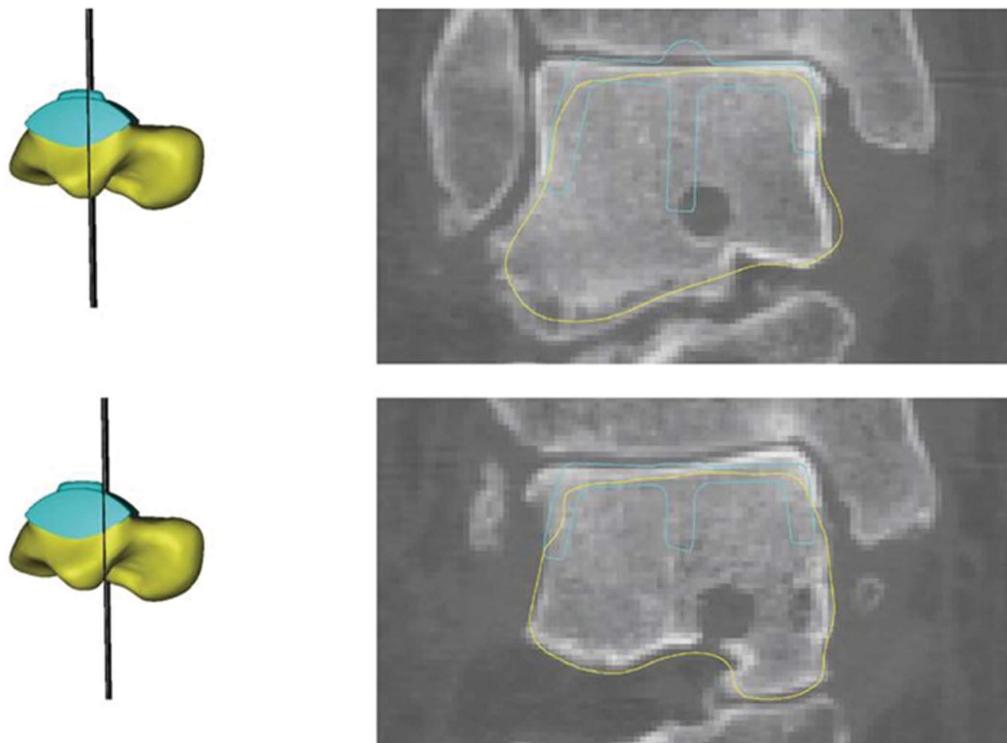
A customized hemiprosthetic was developed using computed tomography and magnetic resonance imaging data of the affected and contralateral talus considering the option of integrating the S.T.A.R. prosthesis (Stryker) into the design.
